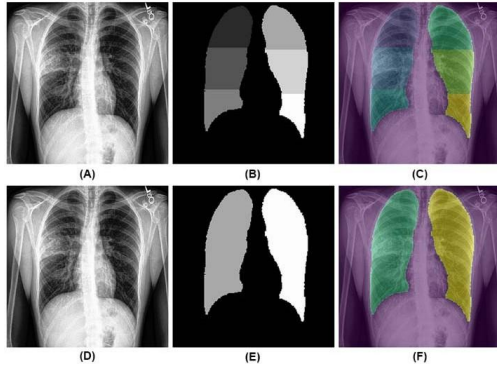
Lung Segmentation. (A, D) Original chest X-ray, lung zones (B) and left-right (E) masks, and chest X-ray overlapped with lung masks (C, F). Source: The authors (2020).
